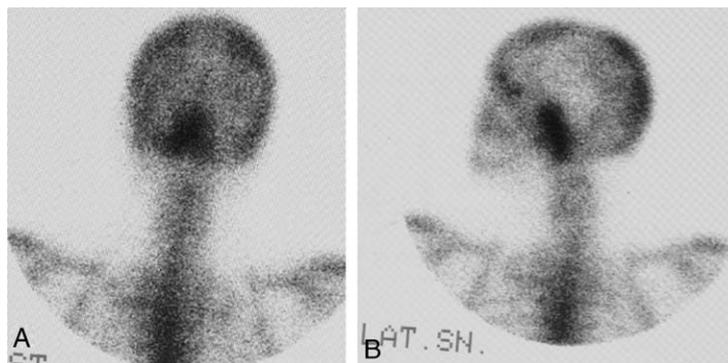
Radionuclide scintigraphic (MDP-Tc99m) images of the skull and cervicodorsal spine in Antero-Posterior Projection (A) and Latero-Lateral Projection (B) showing increased uptake at the clivus region.
